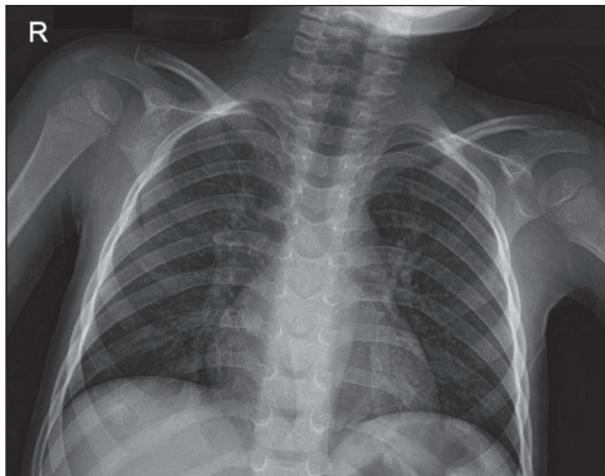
Chest X-ray of a 4-year old patient with Covid-19, admitted for high fever and dry cough. Reticular interstitial densities and bilateral lung involvement are shown.
